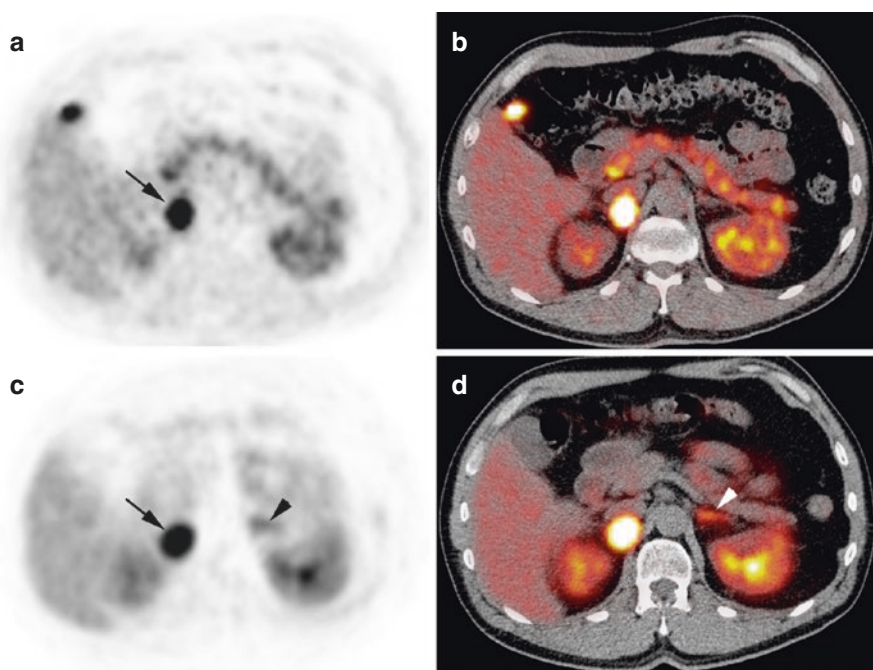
Typical imaging features of PHEO on ¹⁸F-FDOPA PET/CT and ⁶⁸Ga-DOTATATE. Axial ¹⁸F-FDOPA PET (a) and PET/CT (b). Axial ⁶⁸Ga-DOTATATE PET (c) and PET/CT (d). The PHEO was positive on both imaging studies (arrows). Note high ⁶⁸Ga-DOTATATE uptake by the left normal adrenal gland (arrowheads)
